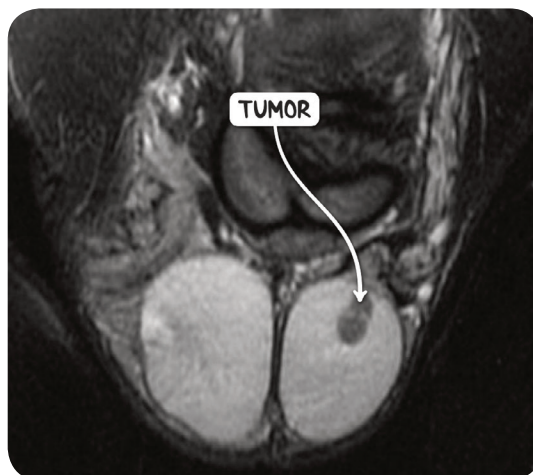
A scrotal MRI scan in the coronal plane demonstrating a tumor of the left testicle.
